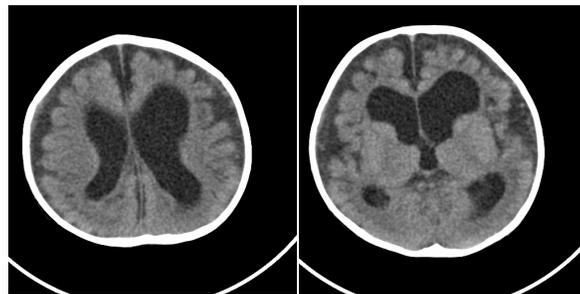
CT images showing obstructive hydrocephalus and subdural effusion.
